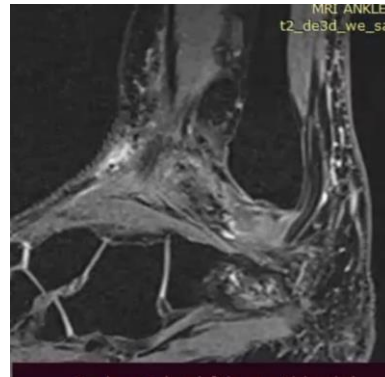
MRI ankle showing inflammation over peroneal tendon
